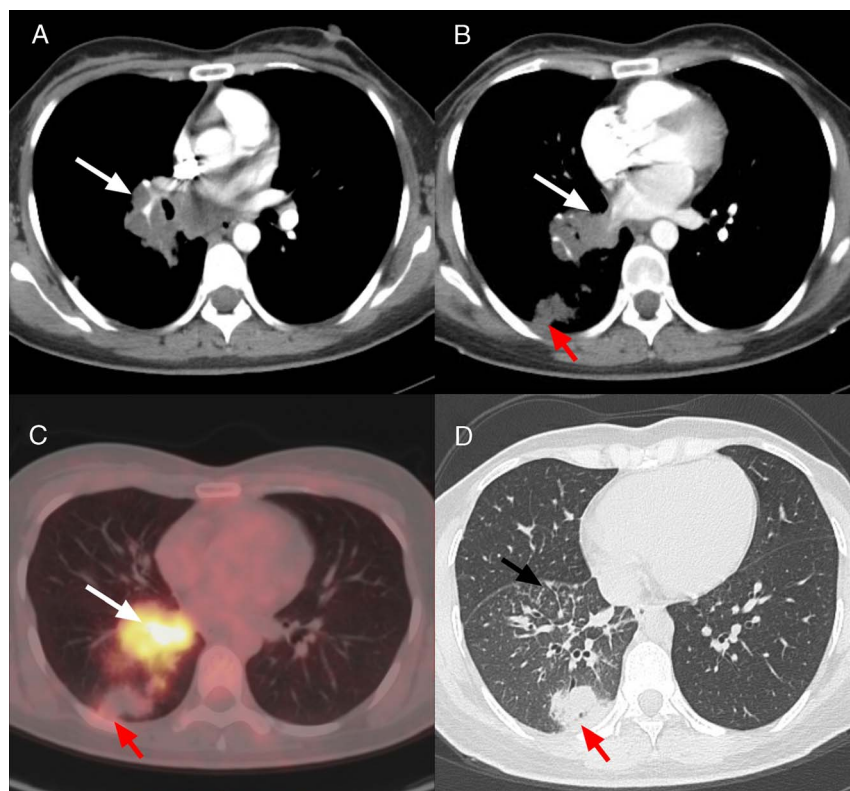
A 32-year-old woman with small cell lung cancer of the right hilum. Axial contrast-enhanced CT (A and B) and PET/CT (C) showed an FDG hypermetabolic mass ($SUV_{max} = 11.6$) in the right hilum (white arrow) with occlusion of the right pulmonary artery and right inferior pulmonary vein. Axial thin-slice chest CT (D) showed slight attenuation of the lower lobe of the right lung and thickening of the interlobular septa (black arrow). Images (B–D) showed a patchy pulmonary infarction in the lower lobe of the right lung (red arrow) with mild heterogeneous hypermetabolism (mismatch between PET and CT).
